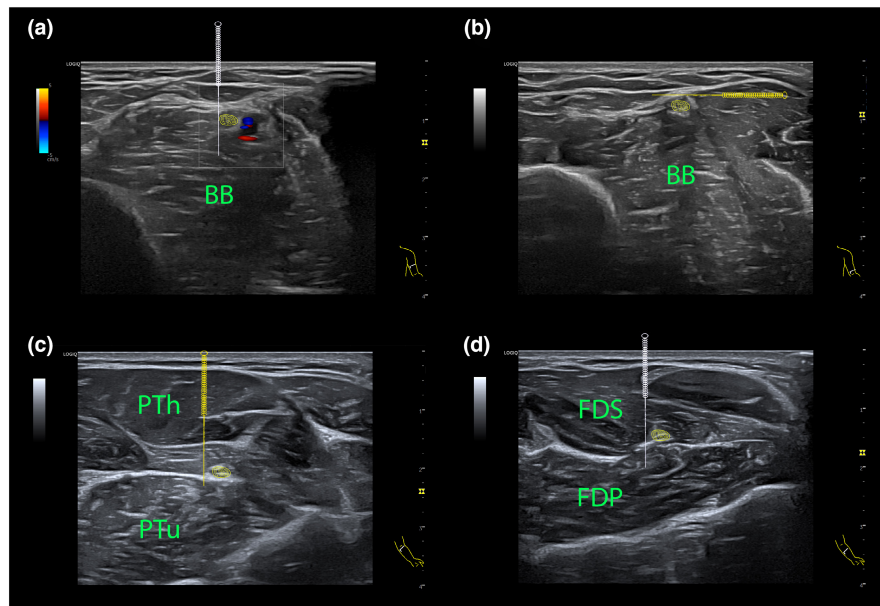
Ultrasound imaging of the arm (biceps brachii, [a] 20 cm superior to the medial epicondyle over, [b] 10 cm superior to the medial epicondyle) and forearm ([c] 3 cm inferior to the medial epicondyle; [d] 10 cm inferior to the medial line of the elbow) points for application of ultrasound-guided percutaneous electrical stimulation in the median nerve. BB, Biceps brachii muscle; FDP, flexor digitorum profundus muscle; FDS, flexor digitorum superficialis; h, humeral head; PT, Pronator teres; u, ulnar head. The circle represents the median nerve.
